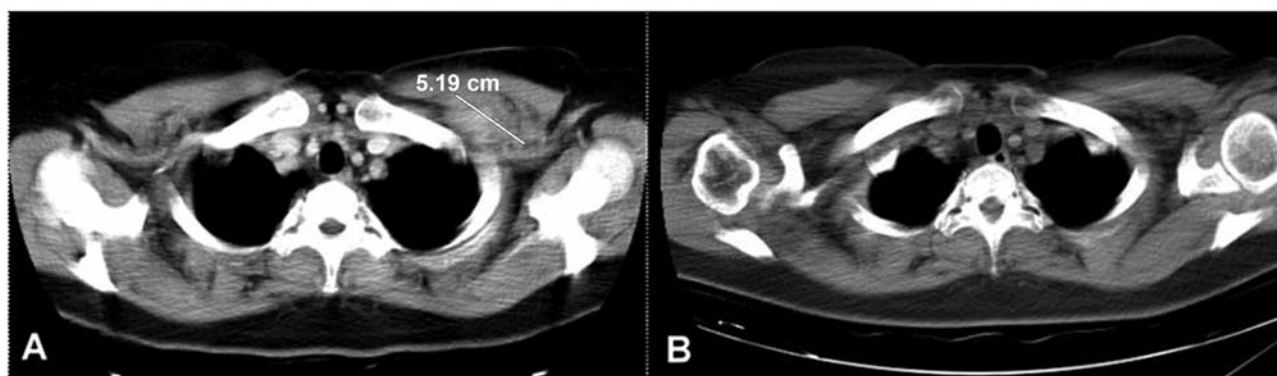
A female patient aged 45 years had a HER2-negative invasive ductal breast carcinoma, with metastases in the chest wall and neck lymph nodes. After receiving 12 cycles of bevacizumab plus docetaxel plus cisplatin, she had a complete response. A: Before treatment, computed tomography (CT) scan in November 2006, showing a tumor mass of size 5.19 cm; B: after treatment, CT scan in March 2007, showing resolved tumor.
